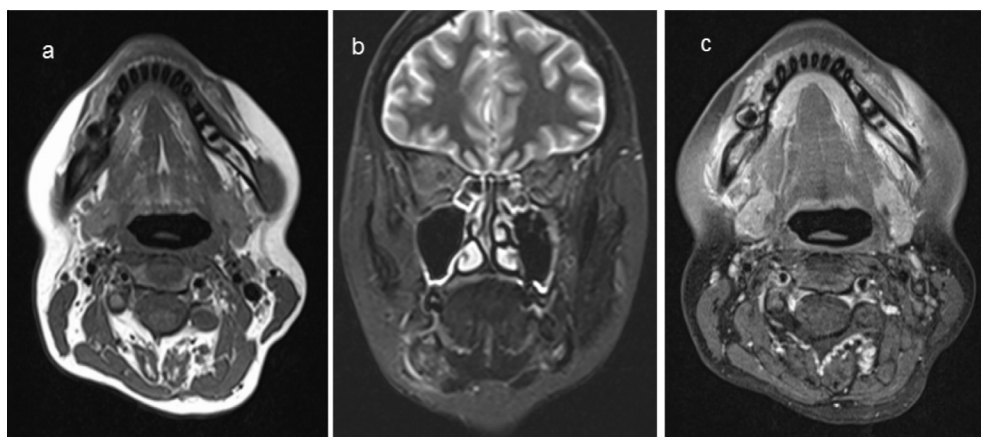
MRI before initiation of bisphosphonate therapy with zoledronic acid. (a) Native axial T1-weighted MRI before the application of contrast medium. Bone marrow signal, which should be hyperintense on T1w images, exhibited decreased signal intensity in the right mandible compared to the other side. (b) Coronal fat-saturated T2-weighted MRI shows increased signal intensity in the right mandible. (c) Axial fat-saturated T1-weighted MRI after administration of a contrast agent reveals decreased signal intensity in the right mandible due to the application of fat suppression, as well as increased contrast medium uptake in the inflamed bone and the adjacent soft tissue.
